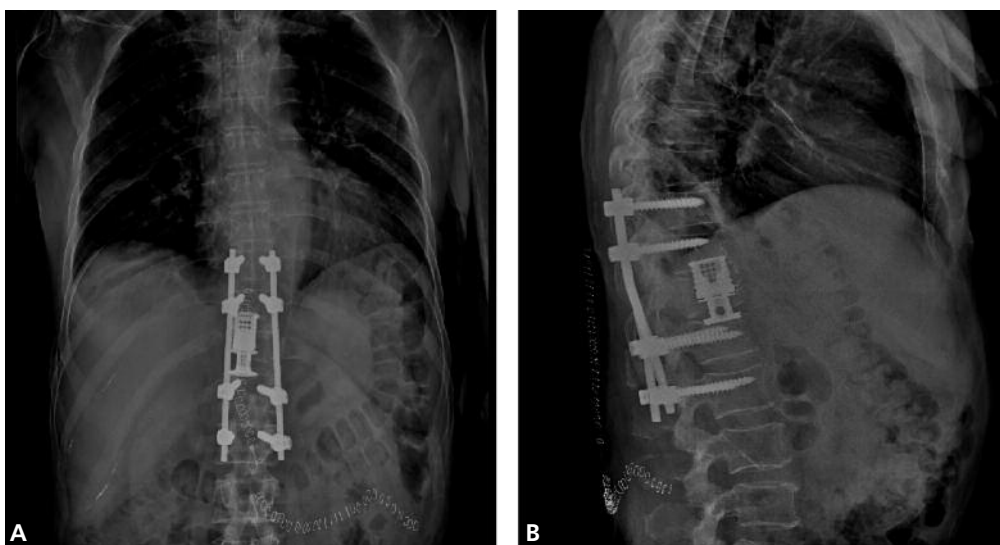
Anteroposterior (A) and lateral (B) post-operative X-rays of T11 corpectomy and reconstruction with expandable cage.
